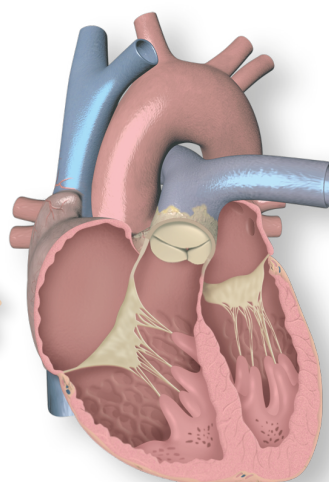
Carcinoid heart disease: clinical features and diagnostic tests. 5HIAA, 5-hydroxyindoleacetic acid; CMR, cardiac magnetic resonance; NP, natriuretic peptides; TTE, transthoracic echocardiography.
